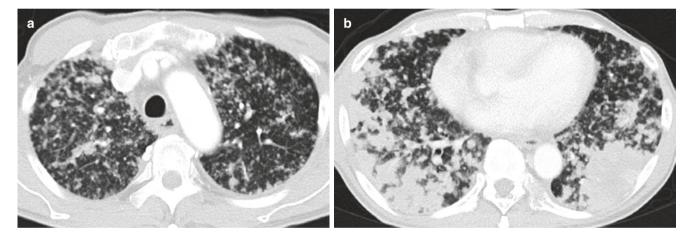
Perilymphatic nodules and masses from lymphoma. (a, b) Axial CT images show innumerable nodules in both lungs with most of the nodules in the subpleural region and along the pulmonary venules. (b) CT image in lower thorax reveals multiple subpleural masses
